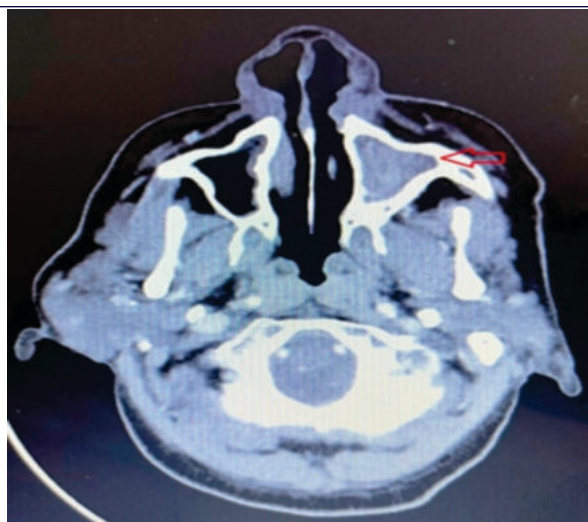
CT PNS showing opacification of left maxillary sinus (red arrow)
